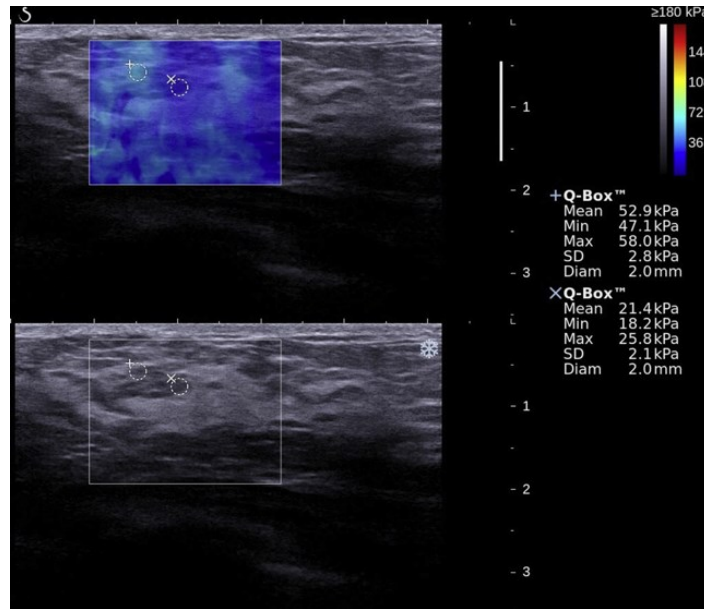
Sonographic images of dense breast, with predominantly hyperechoic glandular parenchyma, with Emax of 58 kPa on shear-wave sonoelastography
